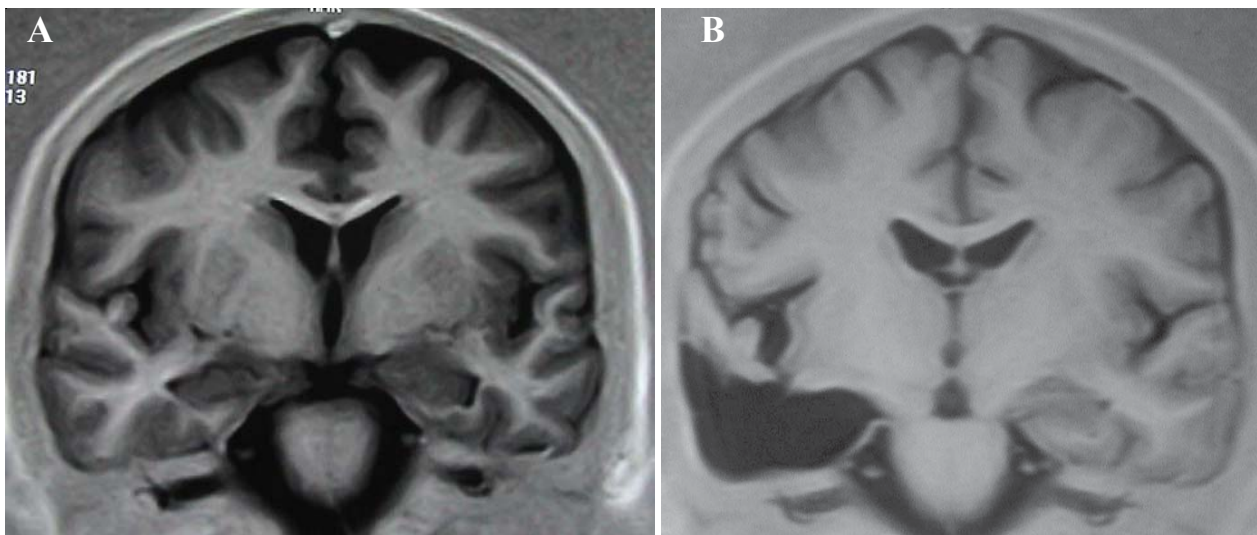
A: Preoperative MRI, T1WI of patient 4 showing right hippocampal sclerosis, B: postoperative image showing extent of surgical resection in tailored ATL which includes removal of hippocampus and amygdala.
